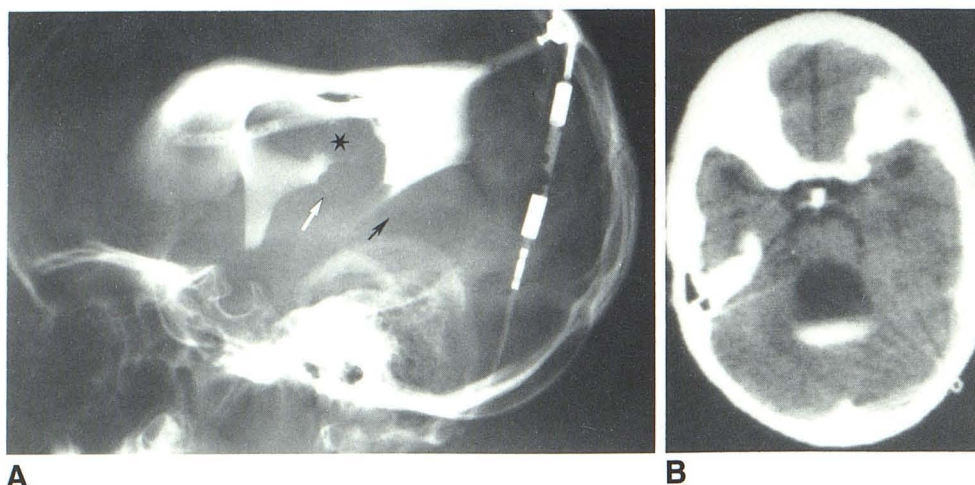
Metrizamide ventriculography followed by CT. A, Supine lateral projection. Significant regression in size of lateral ventricles, and aqueductal stenosis (white arrow). Small amount of contrast material reaches fourth ventricle (black arrow). Adhesions in posterior third ventricle (asterisk). B, Layering of small amount of contrast material in posterior aspect of ballooned isolated fourth ventricle.
